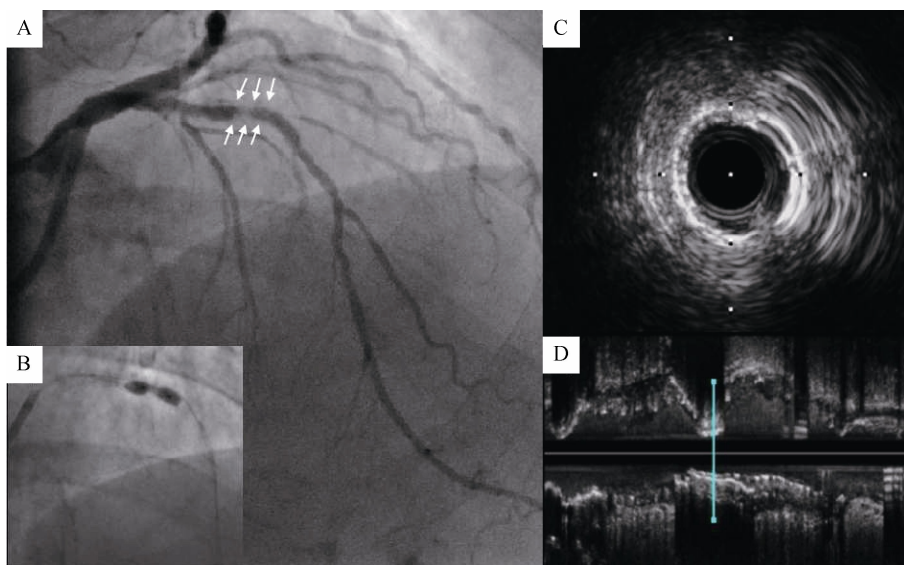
Undilated stent. (A): In the right anterior oblique projection, Taxus 2.75 × 24 mm stent (Boston Scientific Co.) which was deployed three months ago had a waist over mid left anterior descending artery (white arrows); (B): Non-compliant 3.25×12 mm balloon (Quantum balloon, Boston Scientific Co. Natick, MA) with 28 atm could not fully dilate previous stent in mid left anterior descending artery; (C & D): Intravascular ultrasound showed two layers of ring.
